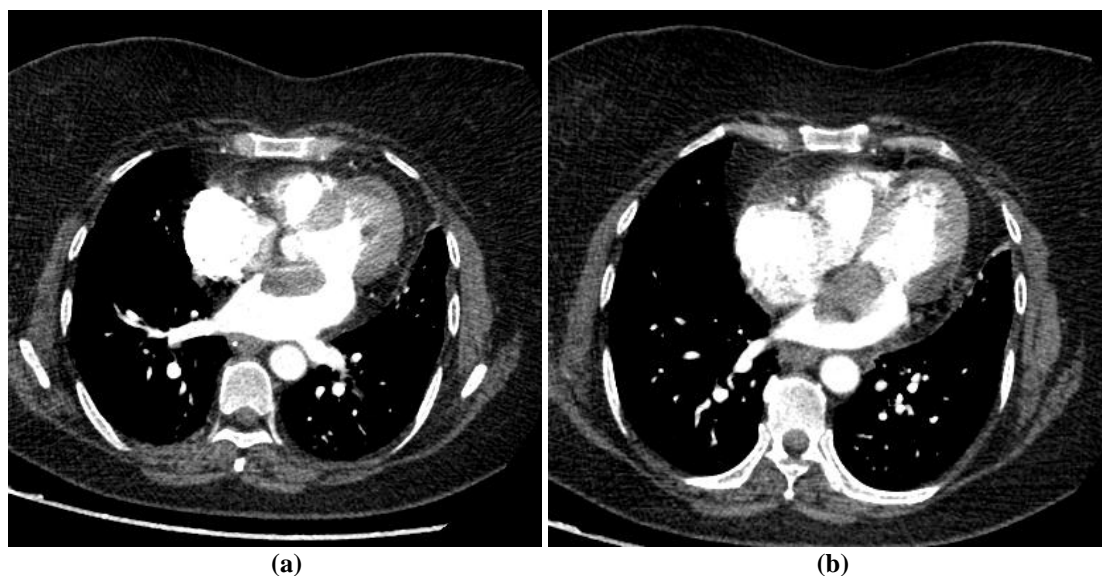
Cardiac CT Axial (A & B) Shows Polypoidal Enhancing Pedunculated Mass In The La With Pedicular Attachment To The Fossa Ovalis Reaching Upto The Mitral Valve.
